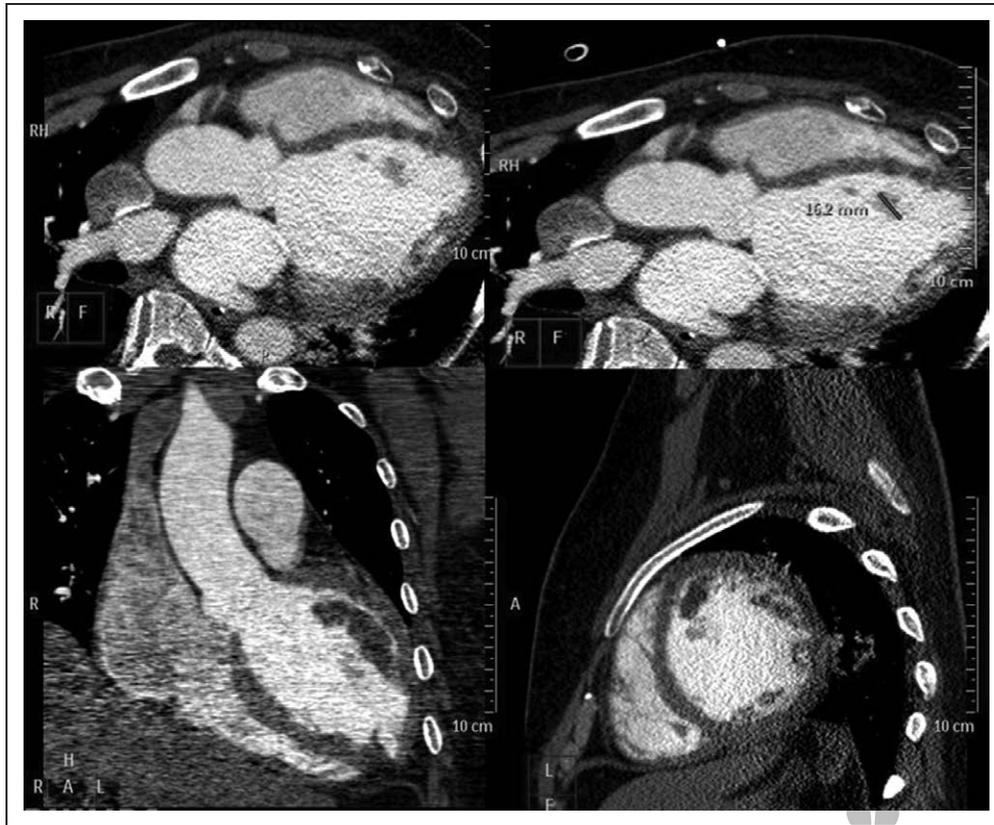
Computed tomography angiogram showing the left ventricular thrombus in various views.
